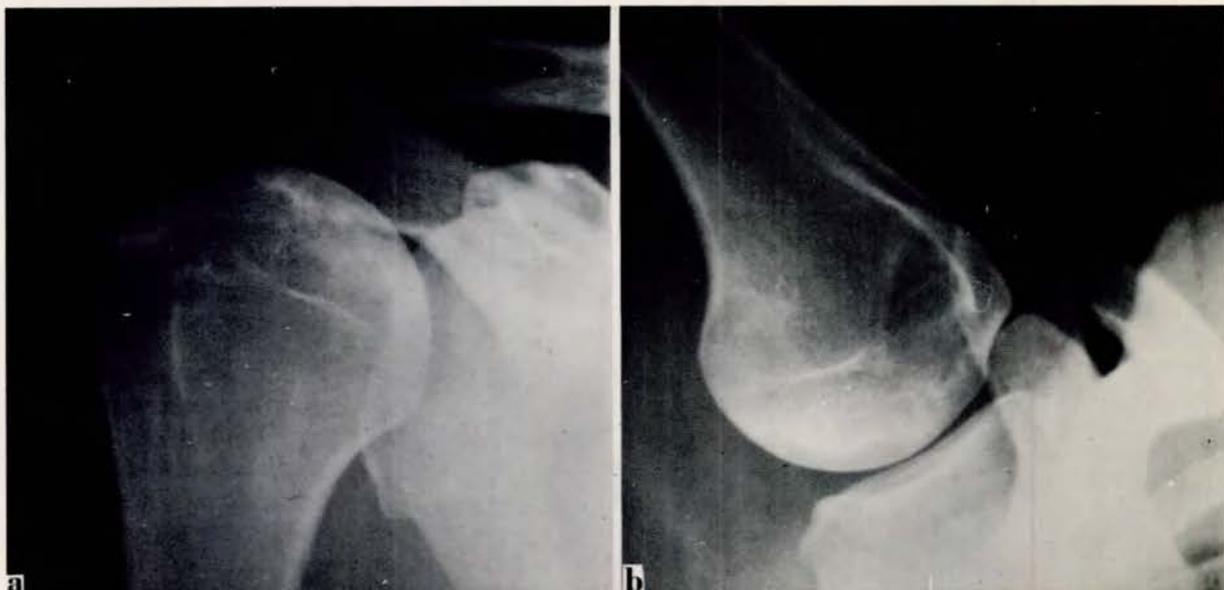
(a) Standard survey X-ray film of a shoulder, in which a juxta-articular lesion can be seen. (b) Inferosuperior view of same shoulder, showing lesion more clearly.
